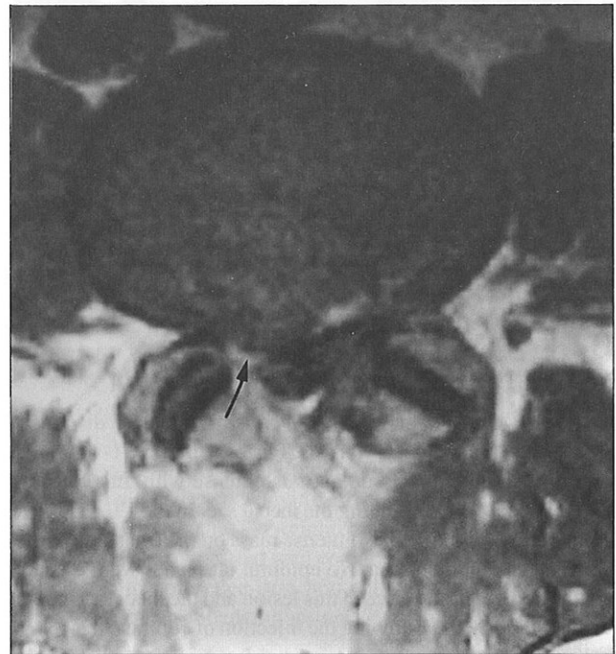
T1-weighted axial image one section superior to Figs 2a and b showing a lesion on the right side of the spinal canal (arrow)
